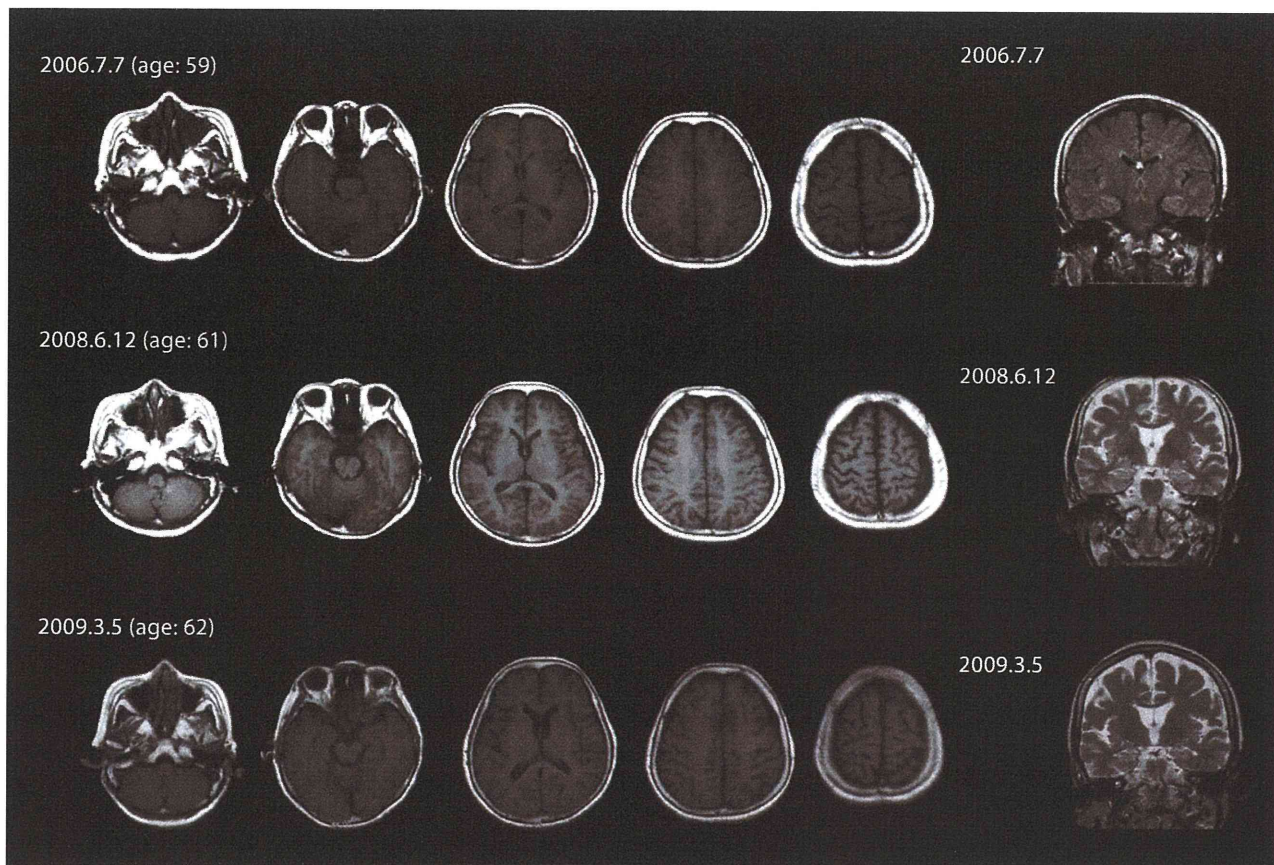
MRI of patient 2 at the ages of 59, 61, and 62. The first MRI scan showed no atrophy of the brain. After her cognition decreased, her MRI images revealed slight cortical atrophy and no atrophy of the hippocampus.
